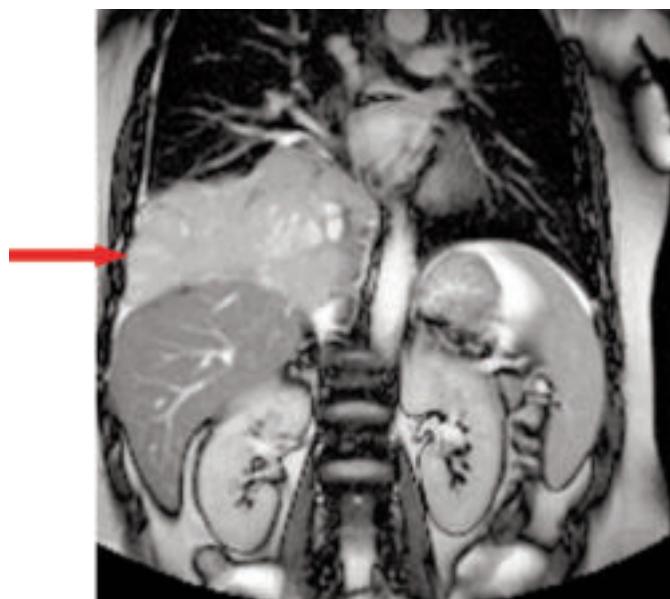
CT scan with coronal reconstruction: thoracic mass located in right side, infiltrating the diaphragm.
